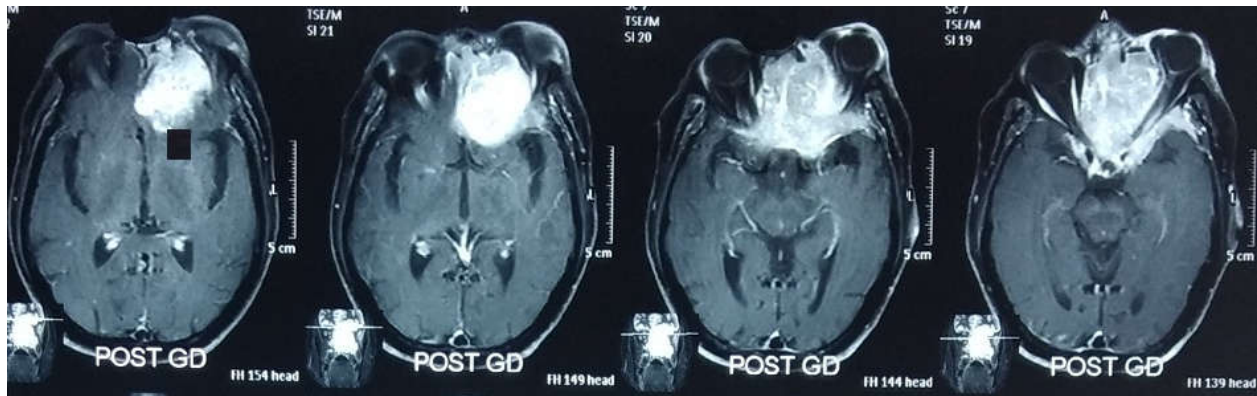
T1 MRI of the sinuses and brain
